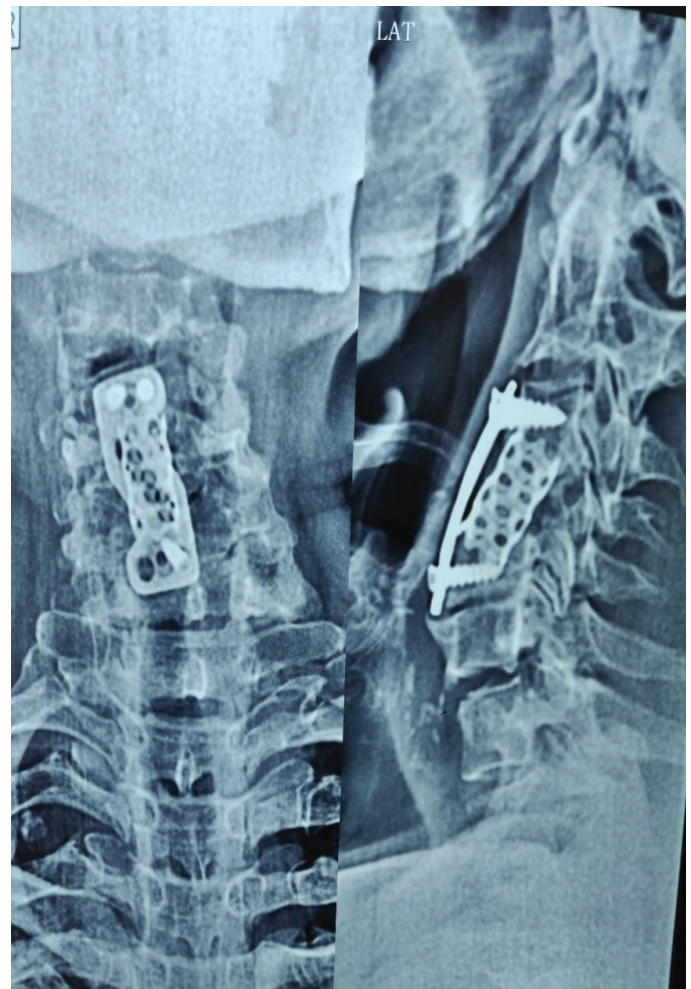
X-ray C-spine AP & Lat view showing missing screw
